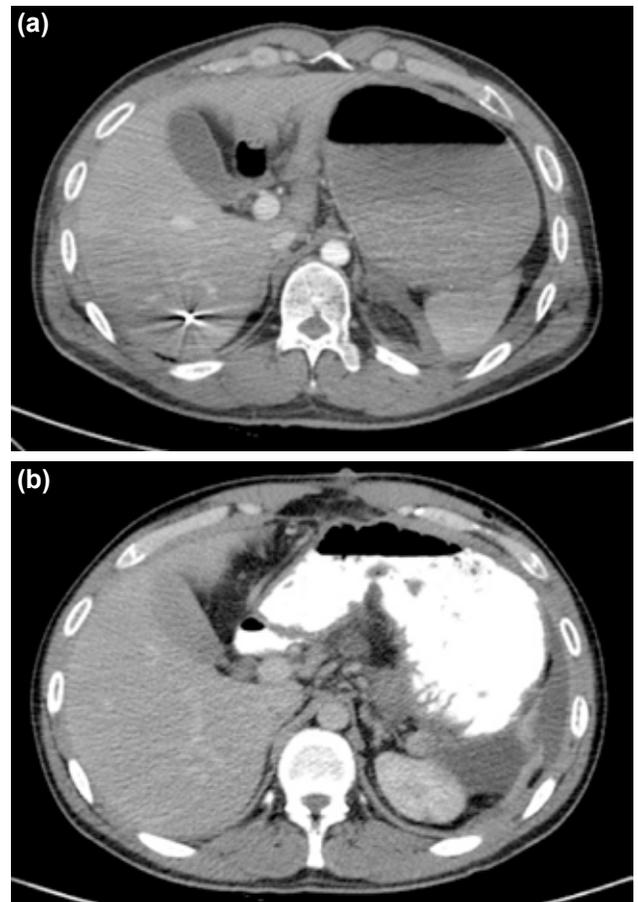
(a) Preoperative axial CT scan showing the pellet located in segment 6 of the liver. (b) The pellet in the liver could not be detected on postoperative day 10 axial CT scan.
